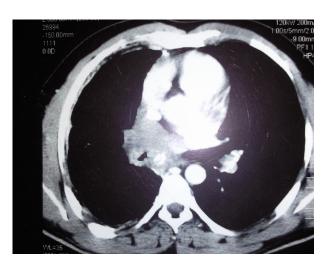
Shows chest X-ray and CT shows elevated right copula of diaphragm and right lower lobe soft tissue mass.
